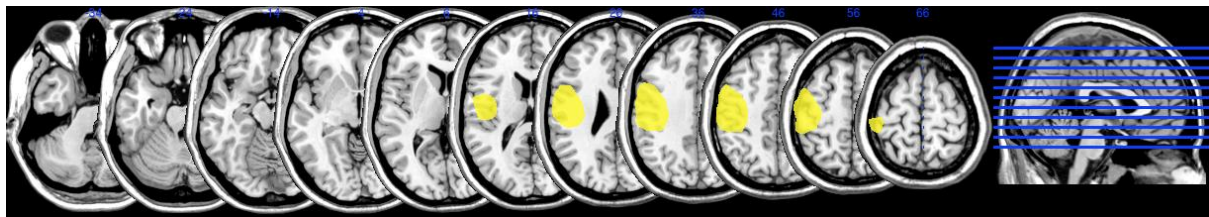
MRI scan of patient CR
